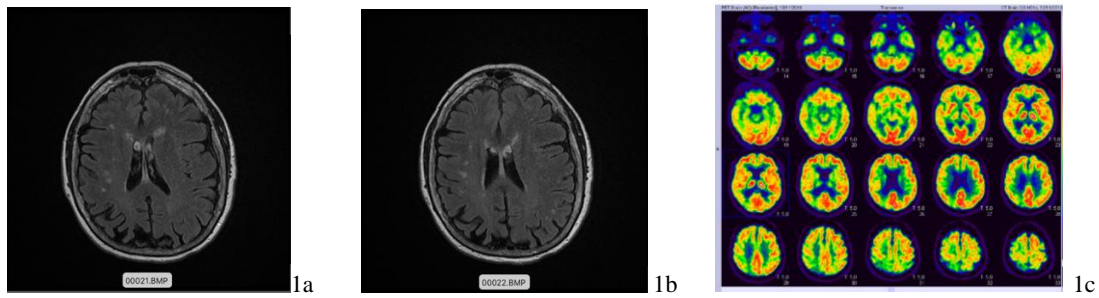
Representation of structural (MRI) and metabolic (PET) impairment of the parietal occipital cortices.
